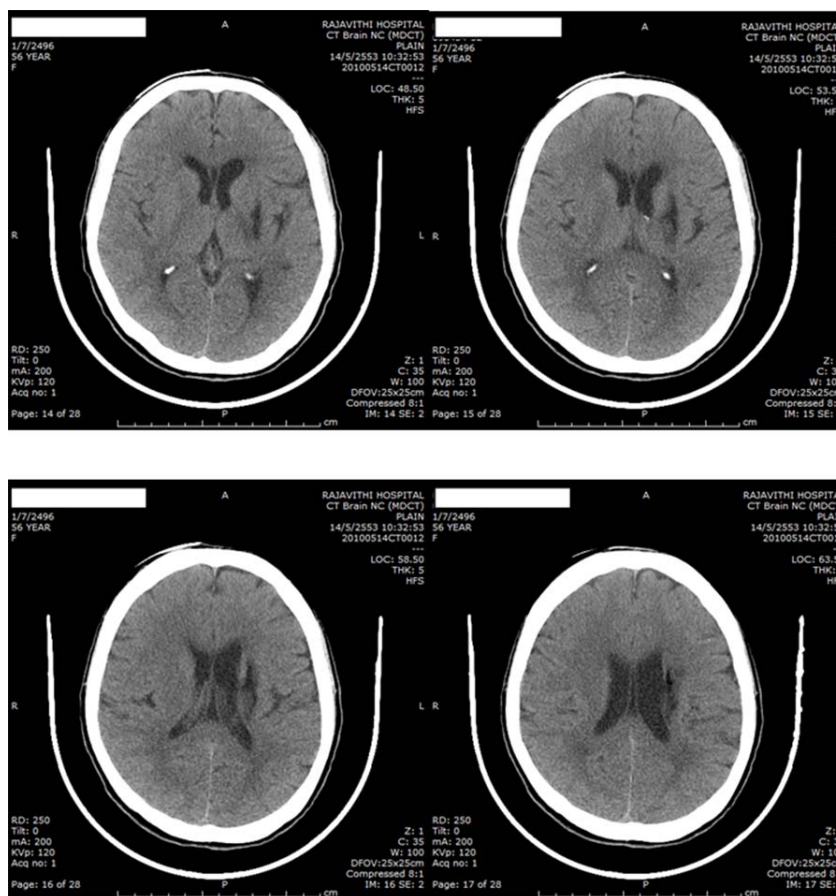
CT of the brain (14/5/2010) revealed small, well-defined hypodense areas of old infarction involving left basal ganglia (posterior limb, internal capsule, external capsule).
